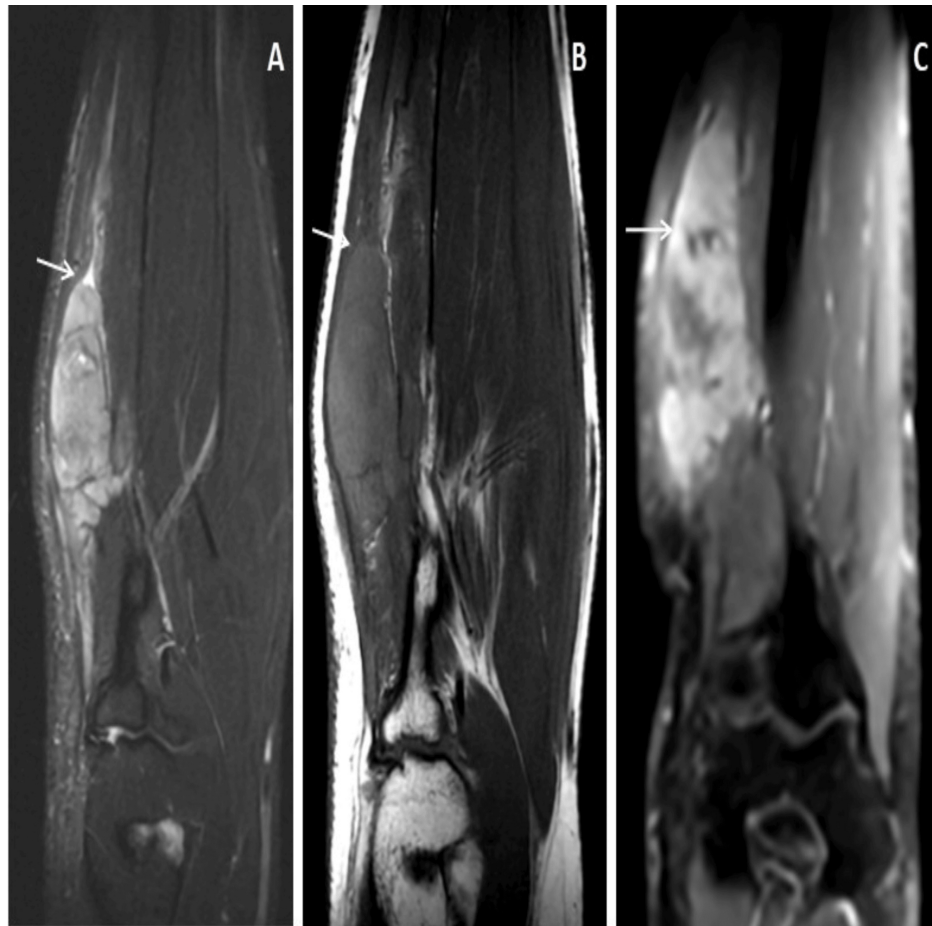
MRI images of the right forearm of the patient.
